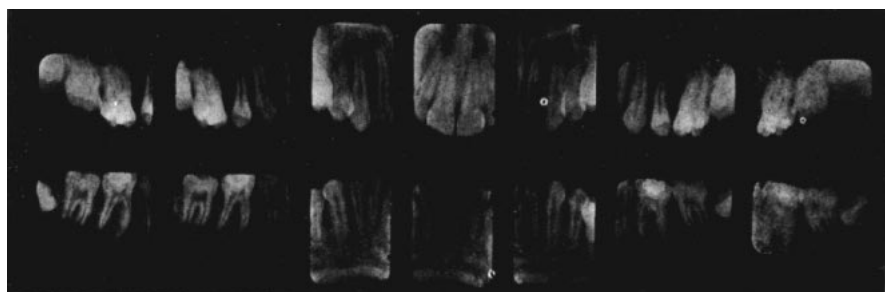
Radiographs of Case III after completion of active treatment.
